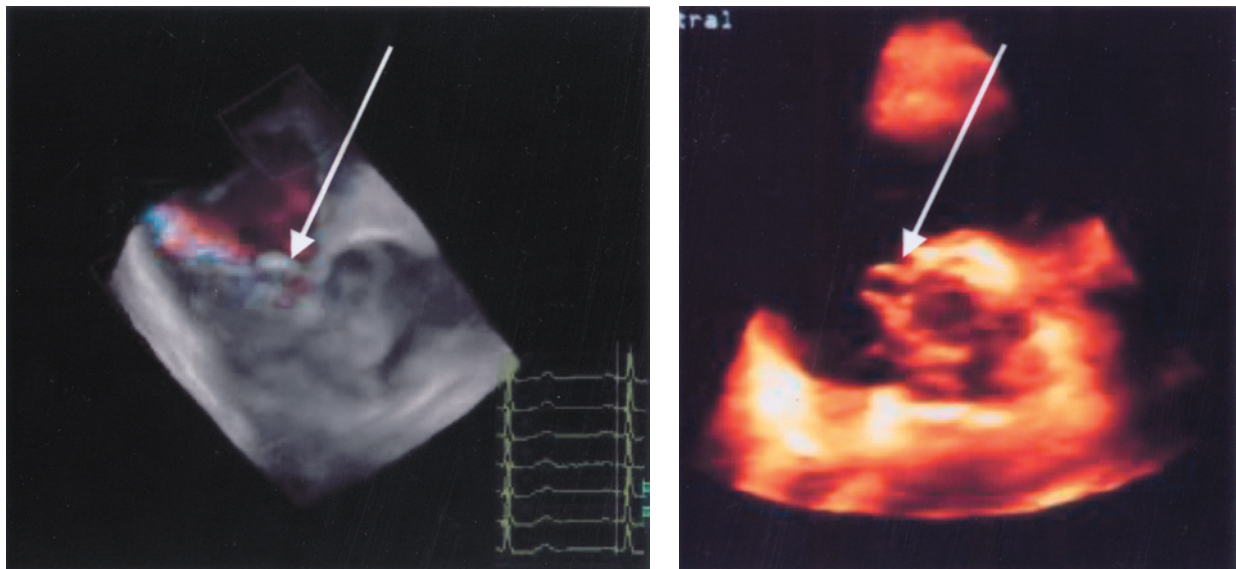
Transthoracic RT3DE images. An aorta-to-right atrial fistula through a ruptured right coronary sinus of Valsalva is seen (arrows).
